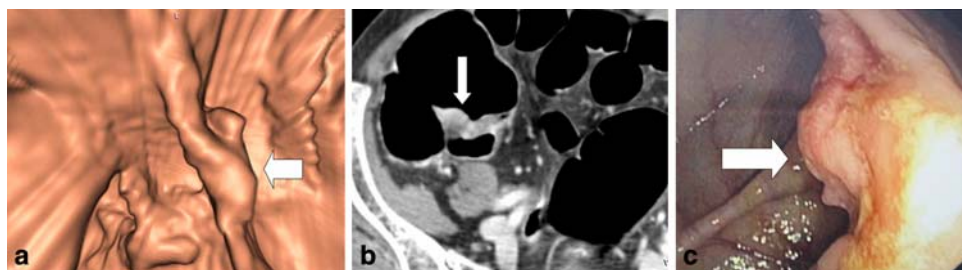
54-year-old man with polyp on the ileocecal valve. A Three dimensional threshold-rendered endoluminal CT colonograph of ascending colon shows a sessile polypoid lesions on the ileocecal valve (*arrow*). B Axial CT scan obtained colon window at same level as A shows a polypoid lesion (*arrow*)
